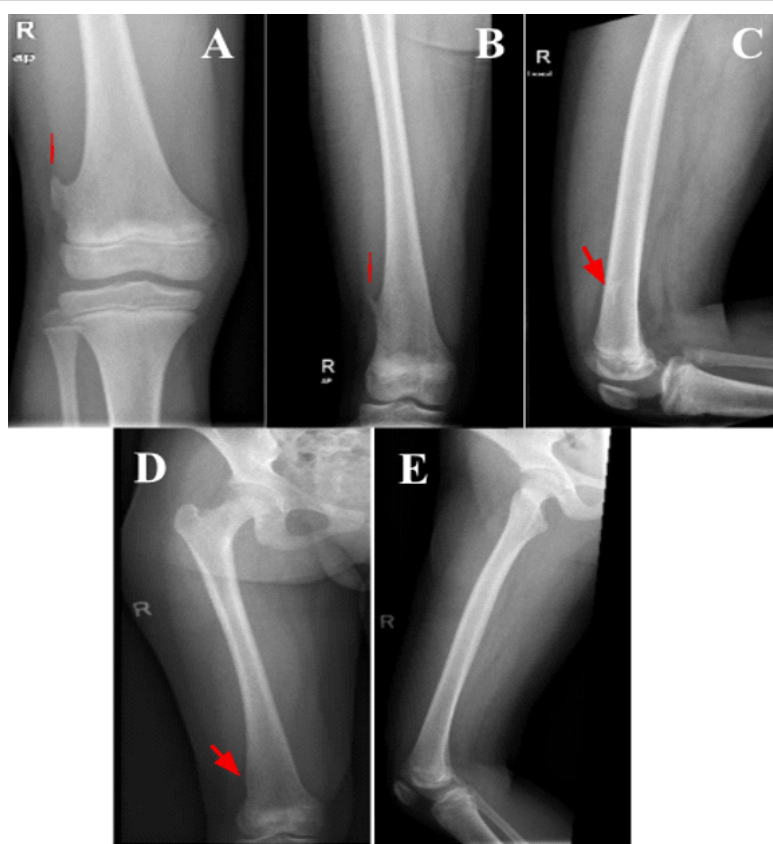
Serial anteroposterior and lateral radiographs of the right distal femur demonstrating a pedunculated osteochondroma arising from the lateral aspect, with corticomedullary continuity and projection directed away from the adjacent knee joint. (a) Initial presentation showing the lesion. (b and c) Follow-up radiographs at 3.5 years demonstrated interval reduction in size. (d and e) Follow-up radiographs at 5.5 years showed near-complete resolution of the lesion with only a small residual cortical projection at the same site.
